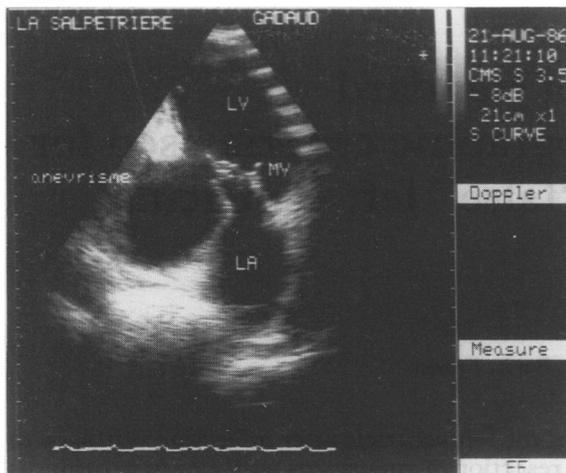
Figure An apical two chamber echocardiogram showing an aneurysm of the inferior left ventricle. LV, left ventricle; LA, left atrium; MV, mitral valve.
